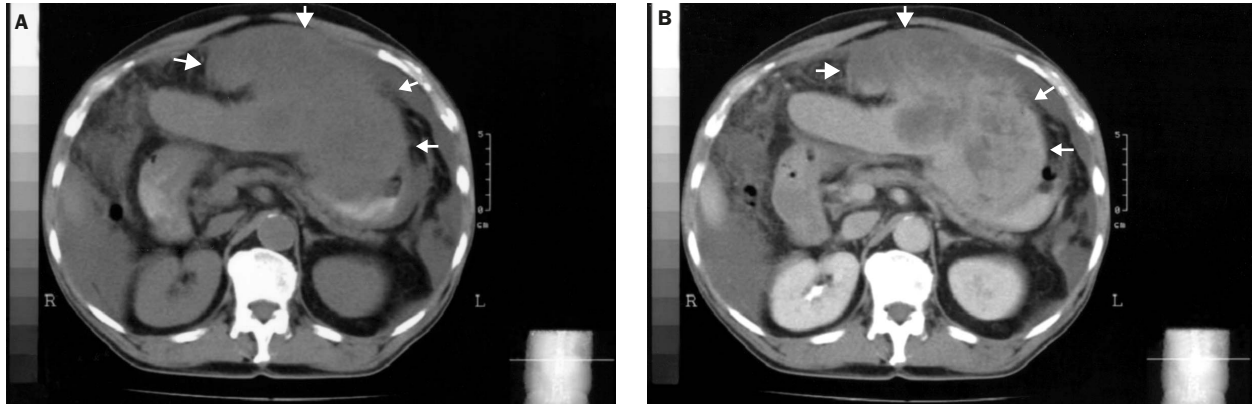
Synovial sarcoma: (A) noncontrast computed tomography (CT) shows a huge, low attenuation mass in the omentum (arrows); (B) postcontrast CT shows an enhanced, heterogeneous lesion involving the inferior liver and anterior stomach (arrows).
